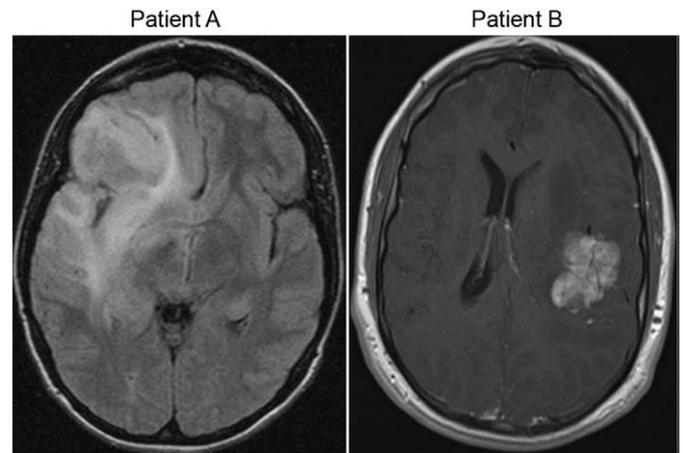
Clinical MRI scans. Axial MRI images of patient A's right frontotemporal tumor and patient B's left parietal tumor.
